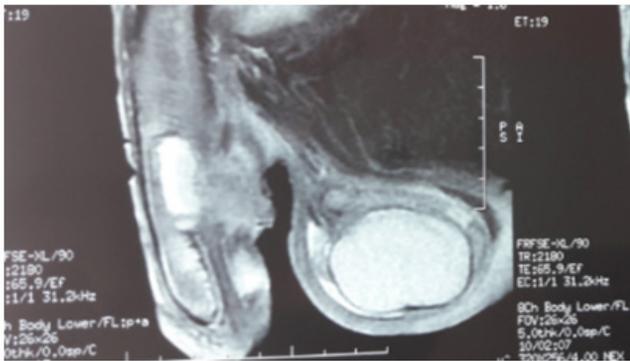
MRI shows a lesional tumoral process of look interesting the lap, face of the yard and invading the corpus and hollow spongiosum
